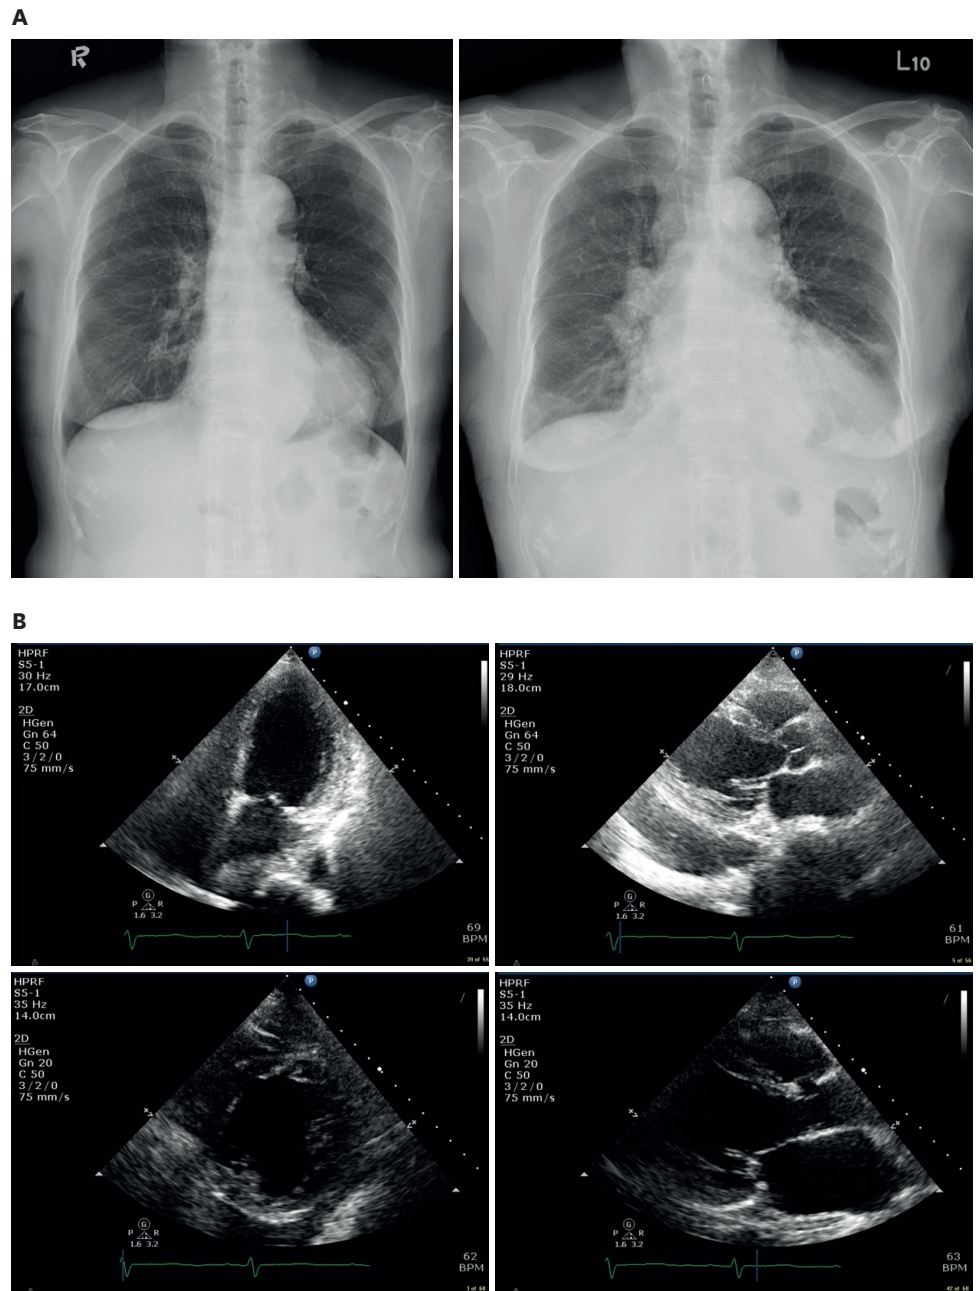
An 81-year-old woman with post-vaccination myocarditis and dilated cardiomyopathy. (A) Cardiomegaly on a chest X-ray (left: baseline image, right: at disease onset). (B) A dilated left atrium and ventricle, as well as global hypokinesia in the echocardiogram.
